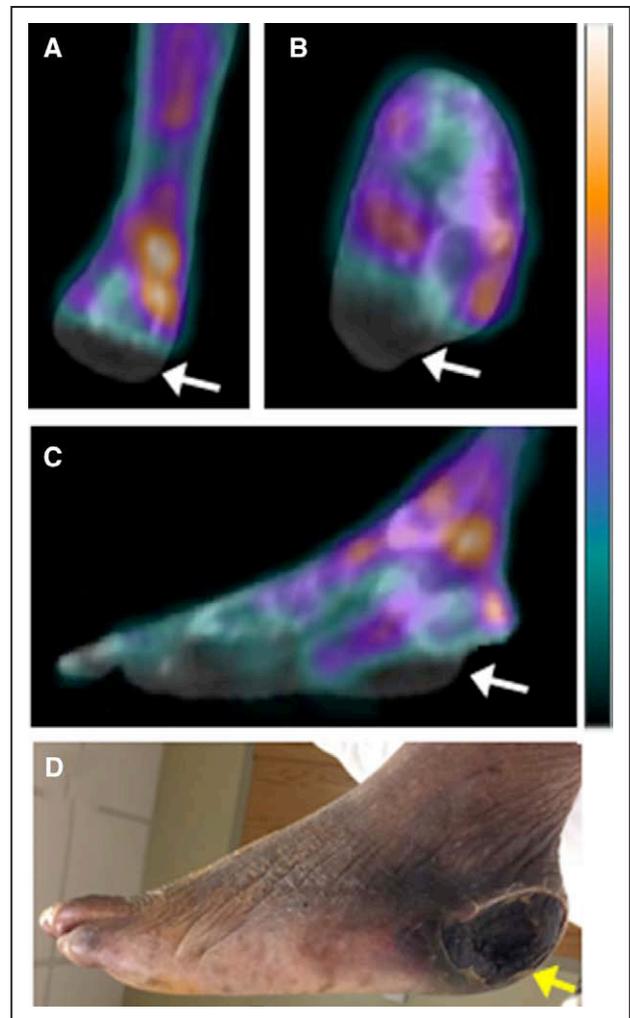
Resting ^{99m}Tc -tetrofosmin single photon emission computed tomography (SPECT)/computed tomography (CT) perfusion imaging in a critical limb ischemia patient with a nonhealing foot ulcer.
